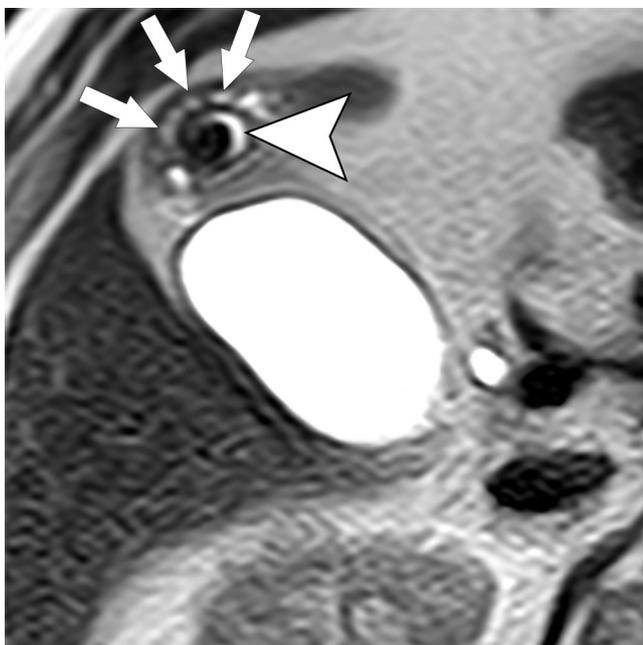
Axial T2-weighted image. Thickened gallbladder wall with a row of intramural cysts – “The pearl necklace sign” (white arrows) and gallstone (white arrow head).
